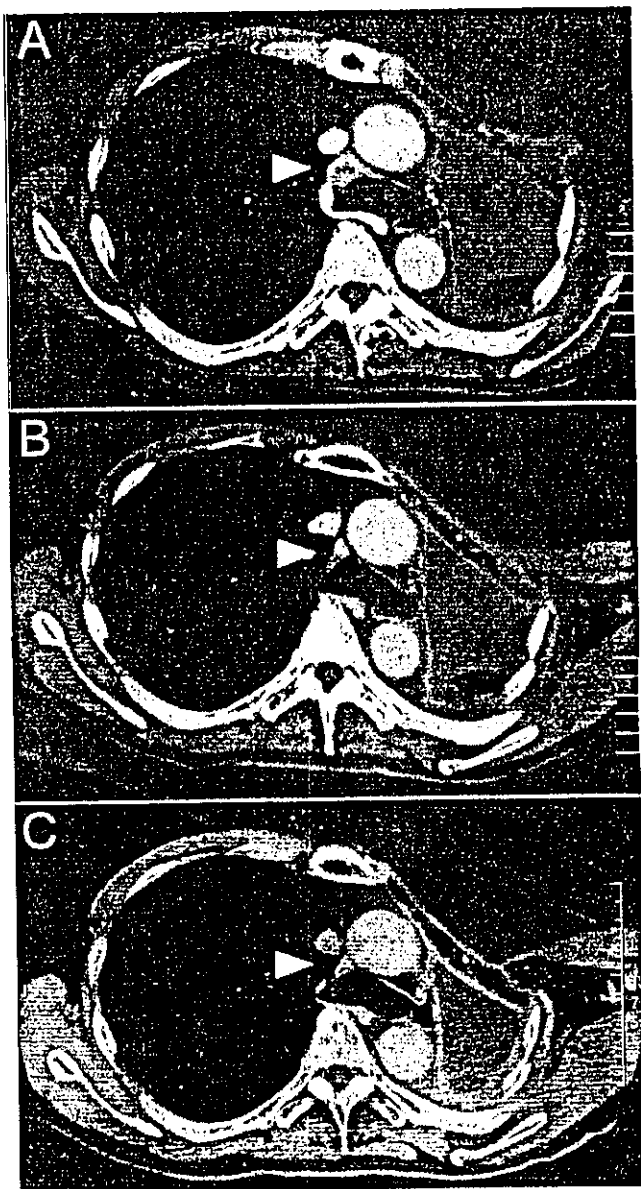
Contrast-enhanced chest CT scans before and after gefitinib treatment. Before gefitinib treatment (a) single mediastinal lymph node (21 x 16 mm, white arrowhead) was detected. Twenty-eight days (b) and 12 months (c) after gefitinib treatment, the mediastinal lymph node was markedly regressed.
